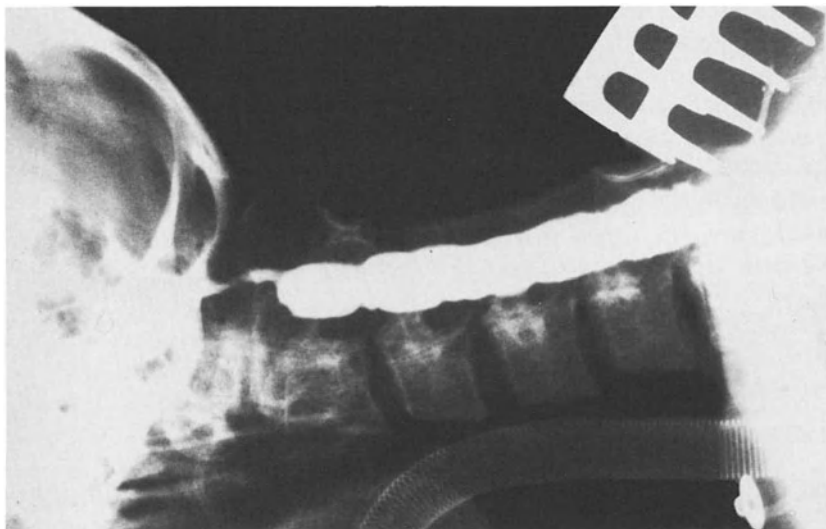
Intraoperative X-ray examination with filling of the intramedullary cavity with contrast medium. Upward communication is visible and the patient was selected for SSS
